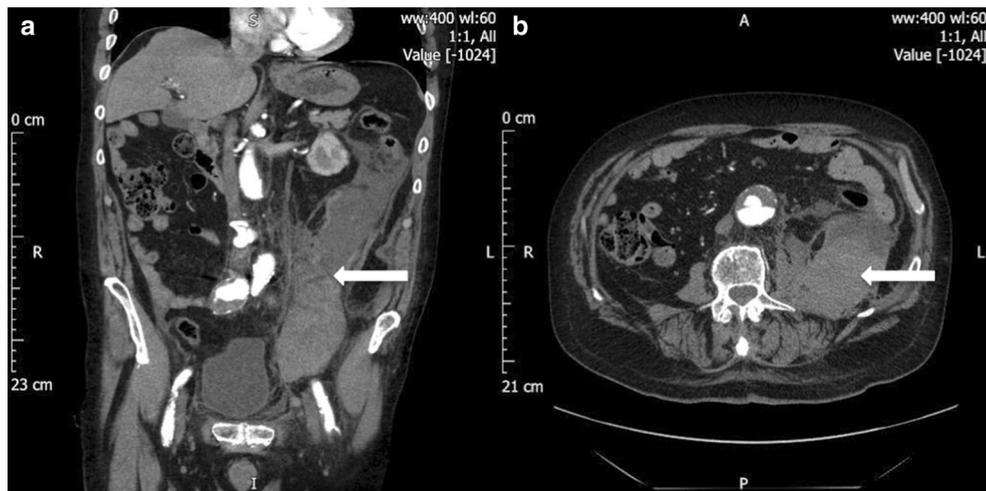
Coronal (a) and axial (b) CT angiogram of our patient demonstrating the retroperitoneal haematoma (white arrows)
